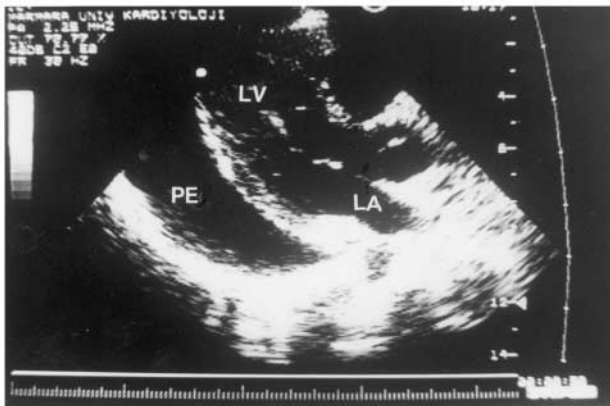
Preoperative echocardiogram of the patient shows a large pericardial effusion (PE). (LV = Left Ventricle, LA = Left Atrium).
